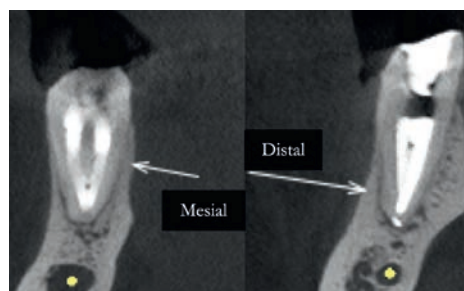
CBCT coronal images (5-month follow-up).
